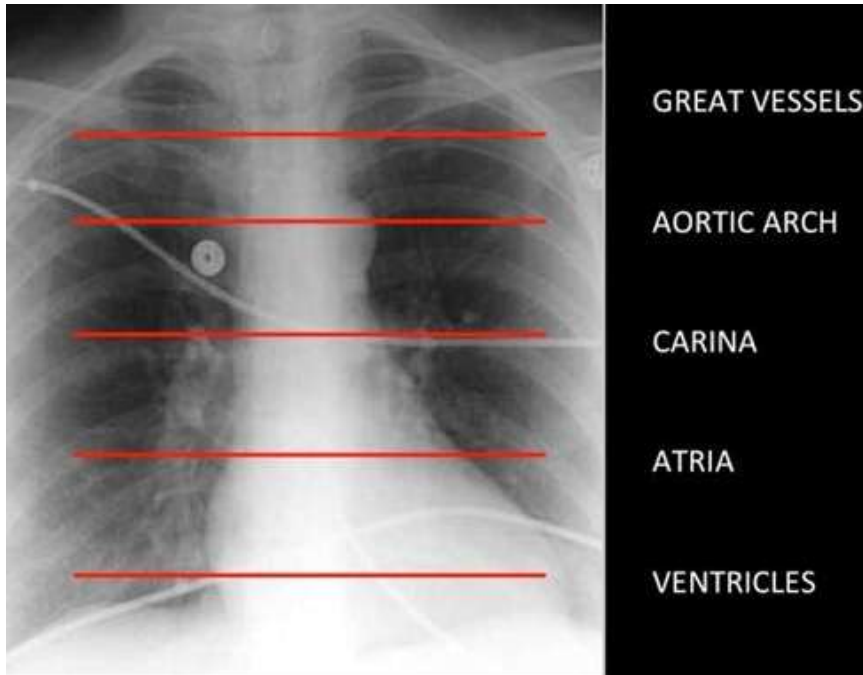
The important structures of the thoracic cavity can be identified at certain key points within the chest as identified on the chest radiograph (*Whiting et al., 2015*).
